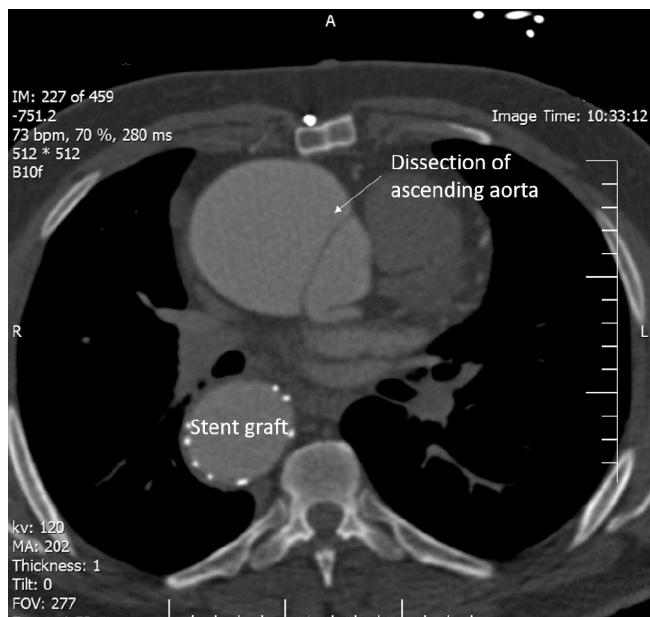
Computed tomography demonstrates the dissection, involving the ascending aorta and extending toward the left coronary sinus.
